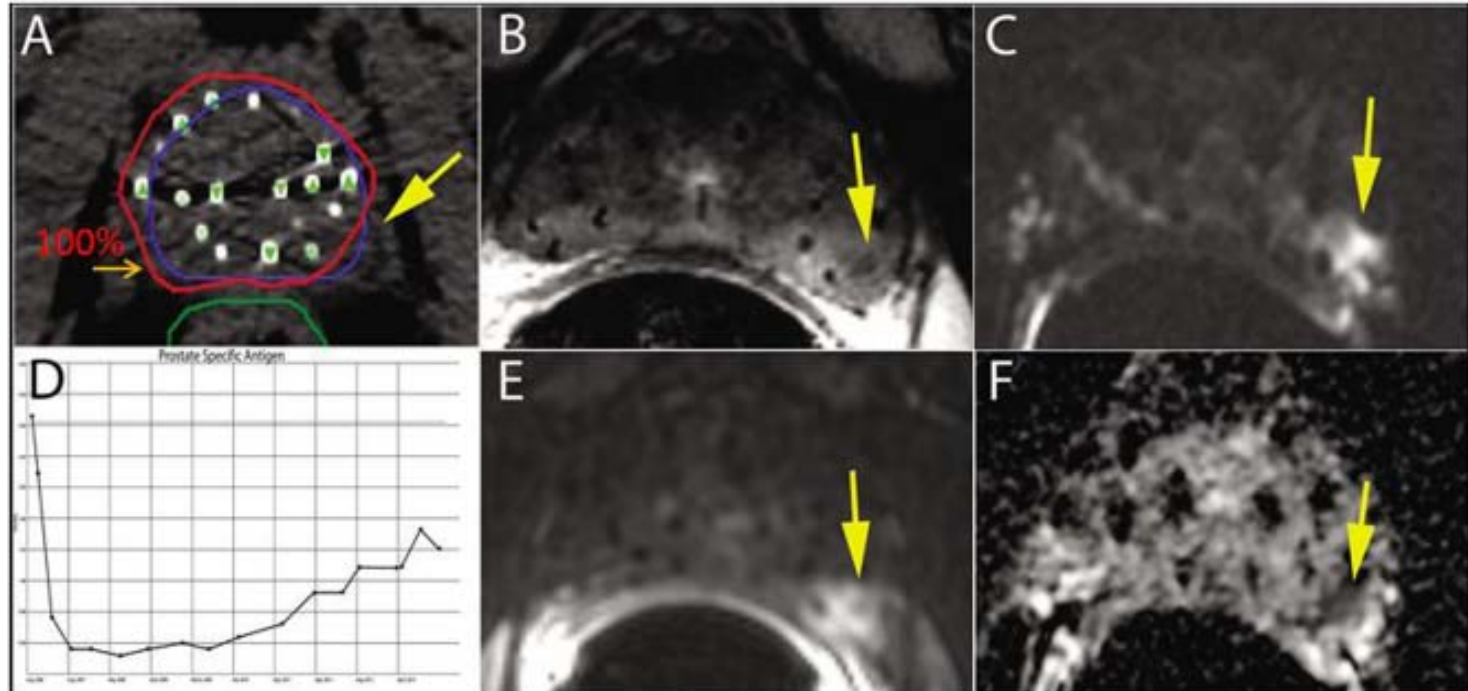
A 75-year-old male presented with a small nodule at the left base of the gland (ie, clinical T2a), PSA of 6 ng/mL, and Gleason Score (GS) of 7 (3 + 4) and was treated with a prostate brachytherapy implant alone to 144 Gy with 125-I (A). Postimplant dosimetry demonstrated a V100 = 97% and a D90 = 177 Gy; however, the left midgland was not covered with the 100% isodose line (A). The patient's PSA reached a nadir of 0.3 ng/mL 18 months after the implant. At 6 years after treatment, he had a PSA of 2.3 ng/mL with a PSA doubling time greater than 12 months (D). Multiparametric 1.5T MRI including T2W (B), DWI (C), DCE (E), and ADC maps (F) localized the recurrence at the left midgland. Metastatic workup showed negative result. Biopsy of the left midgland confirmed adenocarcinoma with a GS of 7 (4 + 3). ADC, apparent diffusion coefficient. (Color version of figure is available online.)
